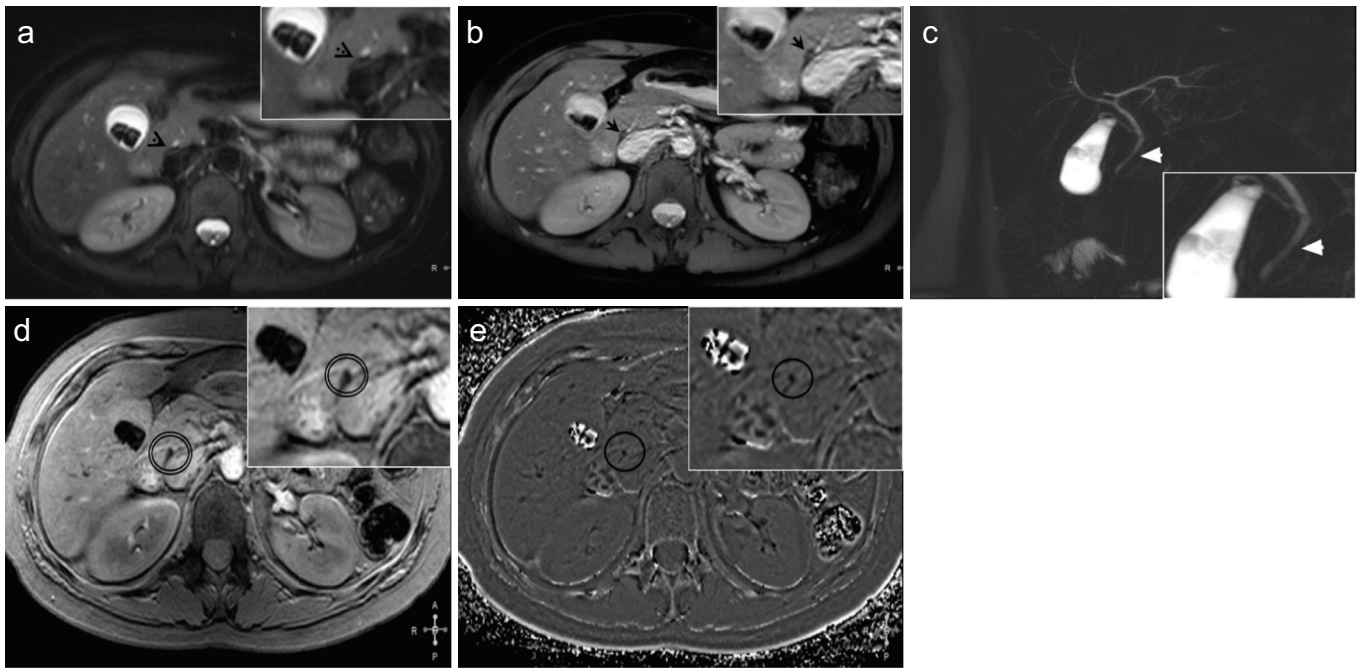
a-e. SWI critical for diagnosis—comparative collage of images from the same anatomical level, from one of the patients where SWI data was critical for diagnosis of identifying the CBD stone. T2-weighted imaging (a) and BTFE (b) are inconclusive in indicating the presence of calculus, while MRCP (c) indicates filling defect and possible sludge. In comparison, SWI data (d, e) clearly demonstrate the calculus (circled) with hypointense signal in magnitude (d) and negative phase signal in the corresponding region of the phase image (e).
